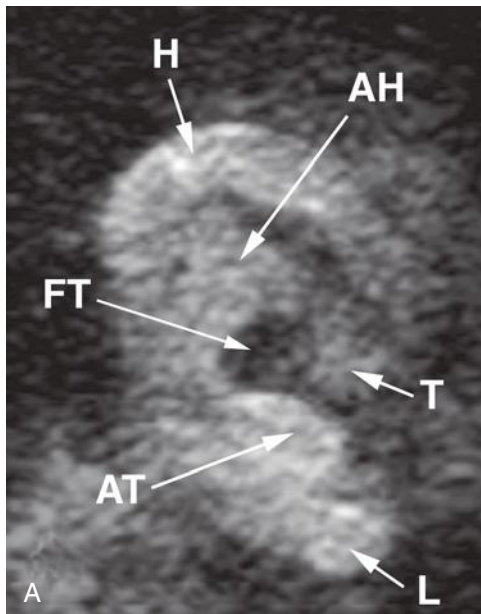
Parasagittal (A) and coronal (B) sonograms of the fetal ear. AH, antihelix; AT, antitragus; EAC, external auditory canal; FT, fossa triangularis; H, helix; L, lobule; T, tragus.
